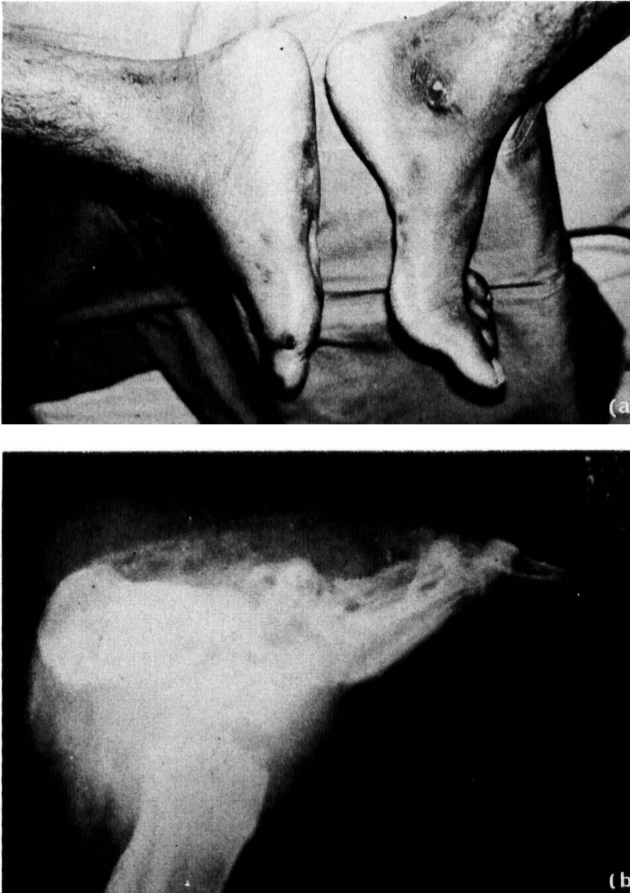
(a). Flattening of the arch of the affected foot; (b) marked radiographic changes of affected foot shown in (a).
